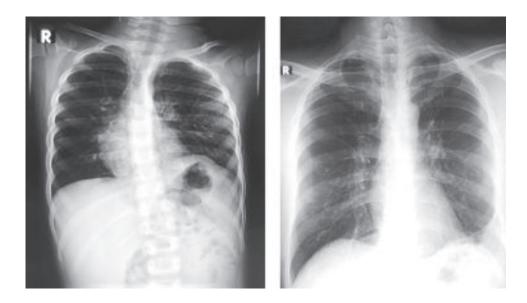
Post operative chest radiograph of left sided eventration of the diaphragm.
